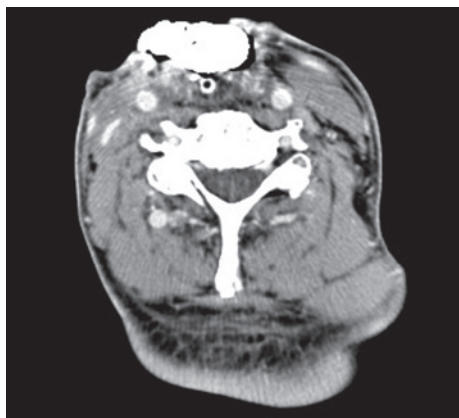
Computed tomography scan revealing a huge fistula packed with iodoform gauze.
